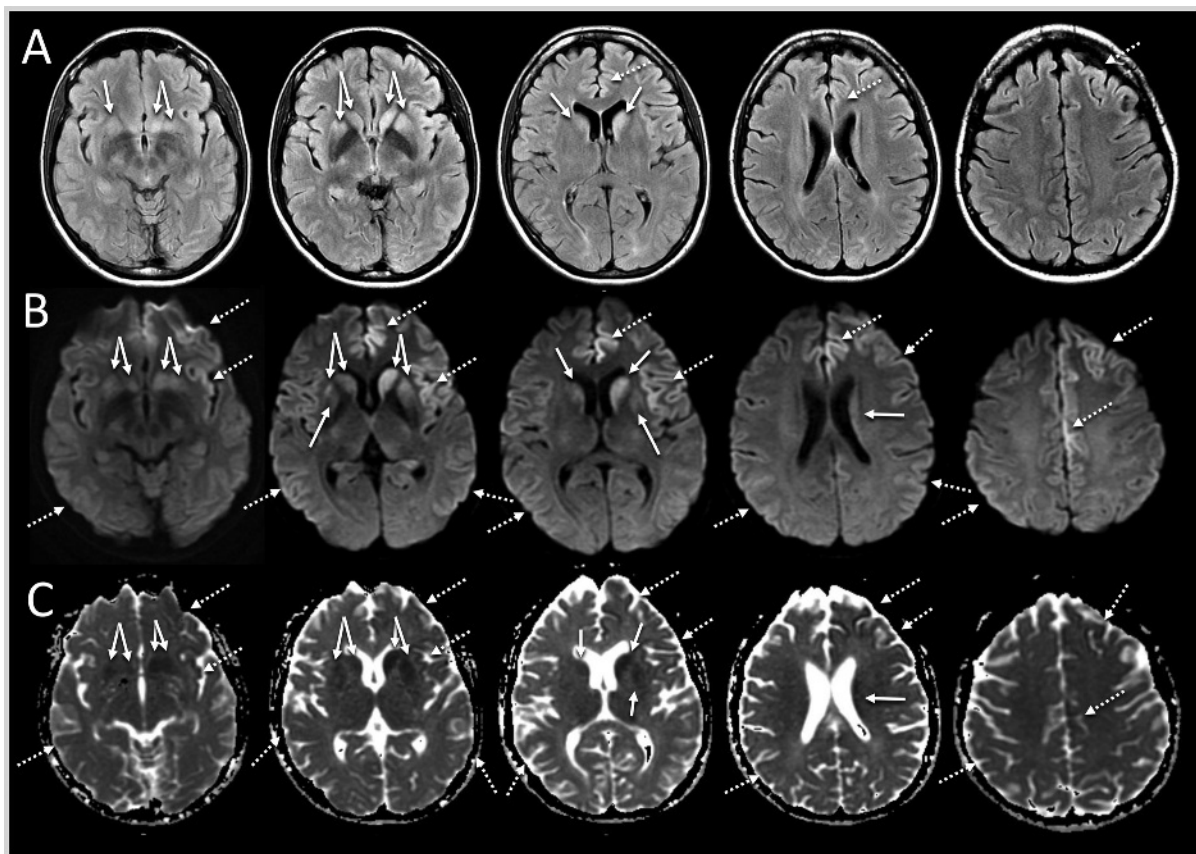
Imaging of the patient in Case 4-2. Fluid-attenuated inversion recovery (FLAIR) (A), diffusion-weighted imaging (DWI) (B), and apparent diffusion coefficient (ADC) map (C) axial MRI of the patient with a *PRNP* E200K mutation. Restricted diffusion is seen in the striatum (solid arrows) and several cortical regions (dotted arrows), including left anterior, medial, and posterior cingulate and frontal, insular, and right temporal-parietal cortices. Patients with this mutation typically have prominent striatal restricted diffusion, often with patchy areas of cortical ribboning.
